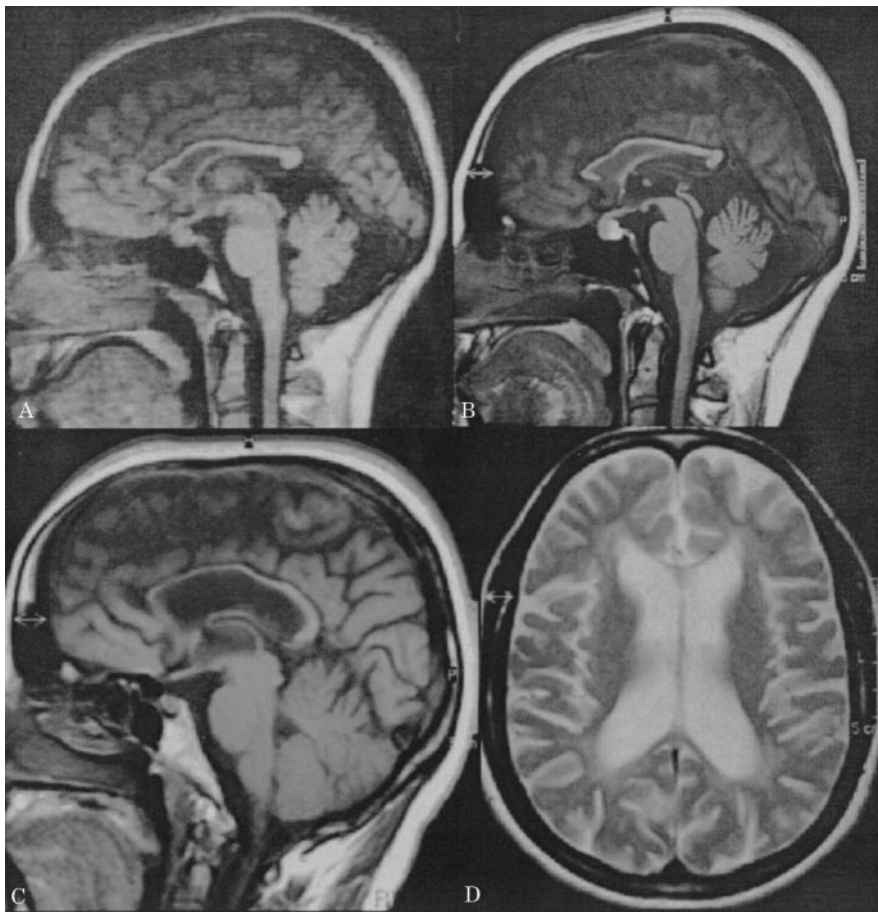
Brain MRI T1-weighted images on the sagittal plane in Patient H5 from Family SM show thinning of the corpus callosum (A) and progression of atrophy of the corpus callosum at follow-up scan obtained 10 years later (B). Brain MRI of Patient H82 from Family DKD shows severe thinning of body and genu of the corpus callosum on sagittal T1-weighted images (C) and hyperintensity of periventricular white matter on axial T2-weighted images (D).
